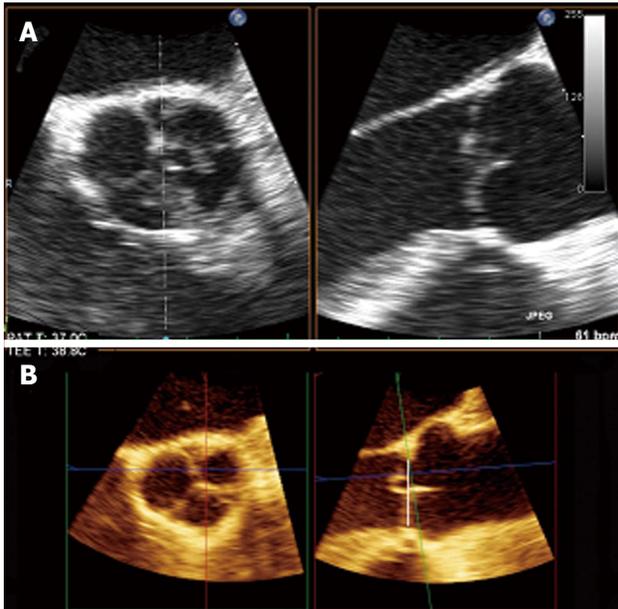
Patient male, 53-year-old. A: On 2 D there is no clear demonstration of prolapse; B: Multiple plane reconstruction of the aortic valve with 3D transesophageal echocardiography: on reformatted image a prolapse of left coronary cusps is shown (right).
